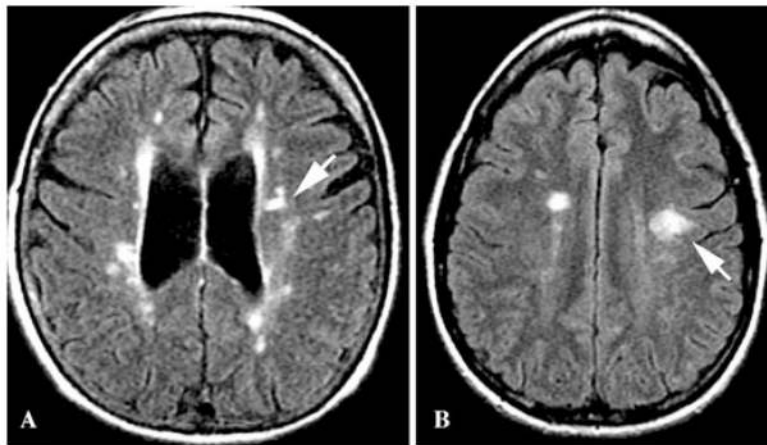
FLAIR MRI in multiple sclerosis. (A) White matter hyperintensity perpendicular to the lateral ventricle (Dawson's finger), shown by the *arrow*. (B) In a second case, the focal area of hyperintensity (*arrow*) corresponded to the initial clinical presentation.²
